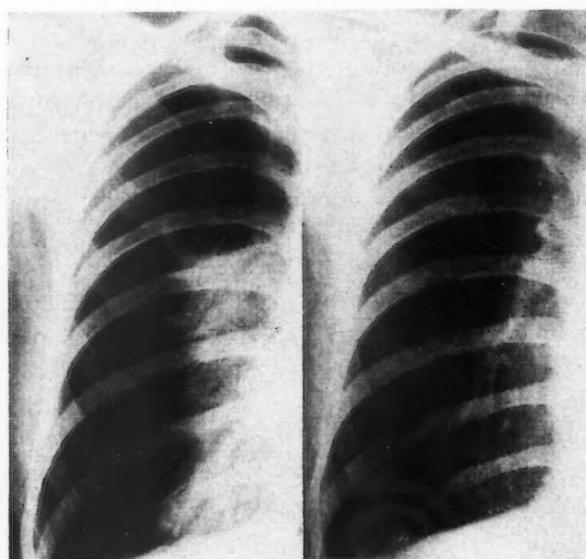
Preoperative (left) and postoperative (right) radiographs of case of single pneumatocele complicated by pneumothorax. This suggested a subpleural bleb which had begun to develop into an emphysematous bulla. Its wall was partly destroyed with the cautery.
